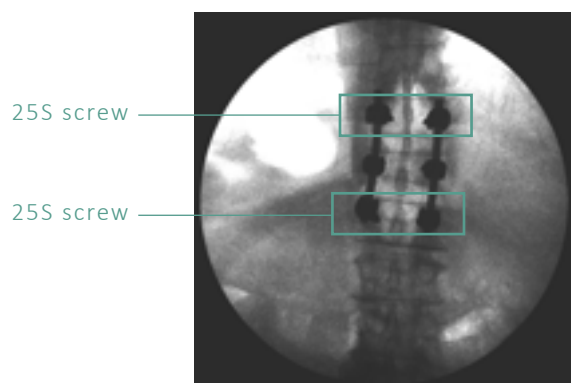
Frontal immediate post-operative X-ray
